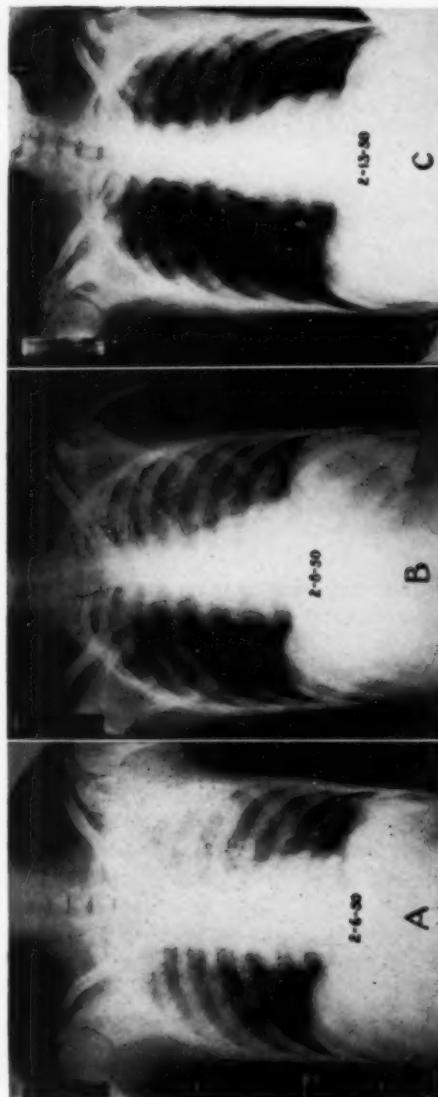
(A) Roentgenogram of chest of 26-year old nurse 30 minutes after sustaining crushing injury of chest. No ribs fractured, no hemorrhage into lungs. Bilateral upper lung field densities due to pulmonary edema (traumatic wet lung). Patient anoxic, cyanotic, disoriented, with frothy serous fluid welling into pharynx.—(B) Good clearing in two days with six hours' initial positive pressure oxygen followed by oronasal oxygen by catheter for 24 hours.—(C) One week later complete clearing of lung fields.
